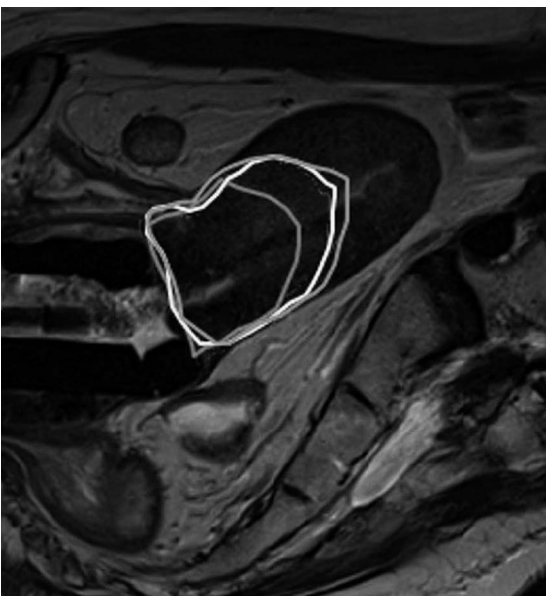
Sagittal view of overlapped HRCTV contours of CT and MRI. Note the underestimation of height with CT-HRCTV contours in a patient with intrauterine disease extension.
